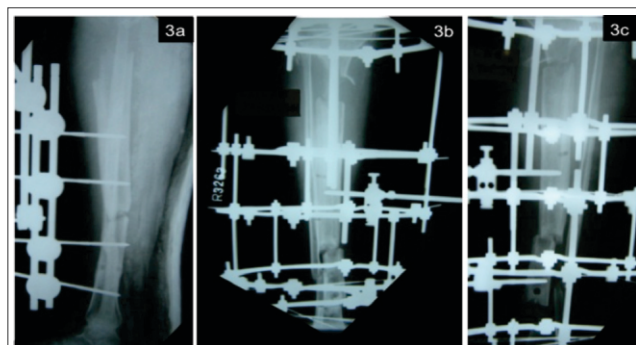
a) Radiograph showing proximal bone loss and distal non union. 3b) & 3c) Radiographs showing distraction at corticotomy site and compression at the site of bone loss with the use of ring fixator – Trifocal Osteosynthesis
